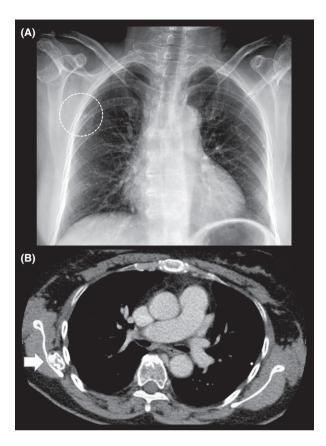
(A) Frontal chest radiograph shows a 1.3 cm density projecting over the right upper lung. Also, a 2 mm calcified nodule is seen between the left posterolateral 5th and 6th ribs, which are likely related to prior granulomatous disease, such as tuberculosis. (B) Noncontrast CT performed 1 month following the chest x-ray in A shows a 1.8 cm (AP) by 1.2 cm (TV) subscapular mass. The lesion is peripherally ossified with central marrow attenuation and preserved adjacent fat planes. These findings are consistent with heterotopic ossification (HO).
